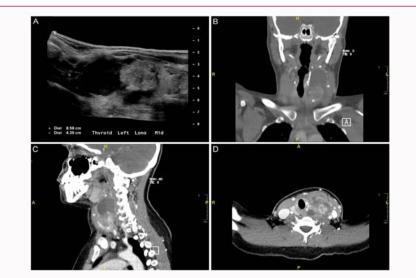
Ultrasound of the left thyroid, longitudinal view (A), and neck CT with intravenous contrast, coronal view (B), sagittal view (C), and axial view (D). See text for detail.
